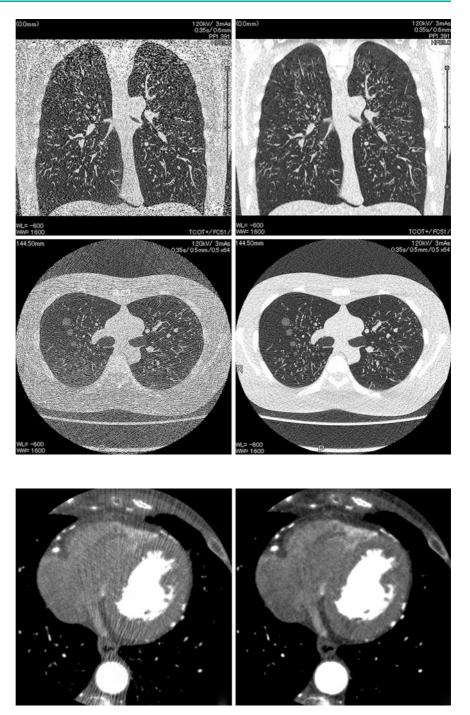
Cardiac CTA: FBP reconstruction (*left*) and AIDR 3D reconstruction (*right*) (DLP of 29 mGy cm and an effective dose of 0.4 mSv). (Courtesy of Monash Medical Center)
